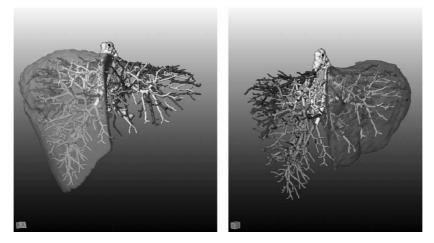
Three-dimensional reconstruction of vascular and biliary anatomy of a donor liver by means of MeVis-CT[©] [43,44].
